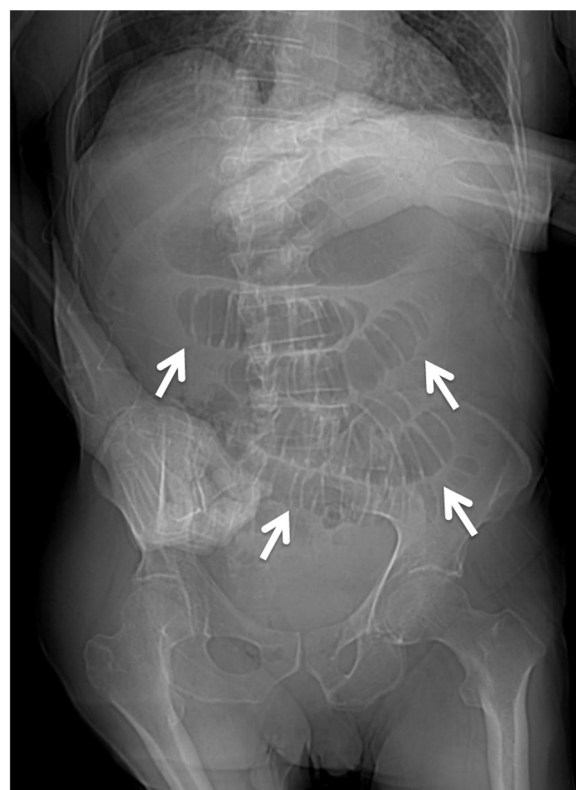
Abdominal X-ray showing small bowel loops distension (arrows) with absence of free abdominal air.
